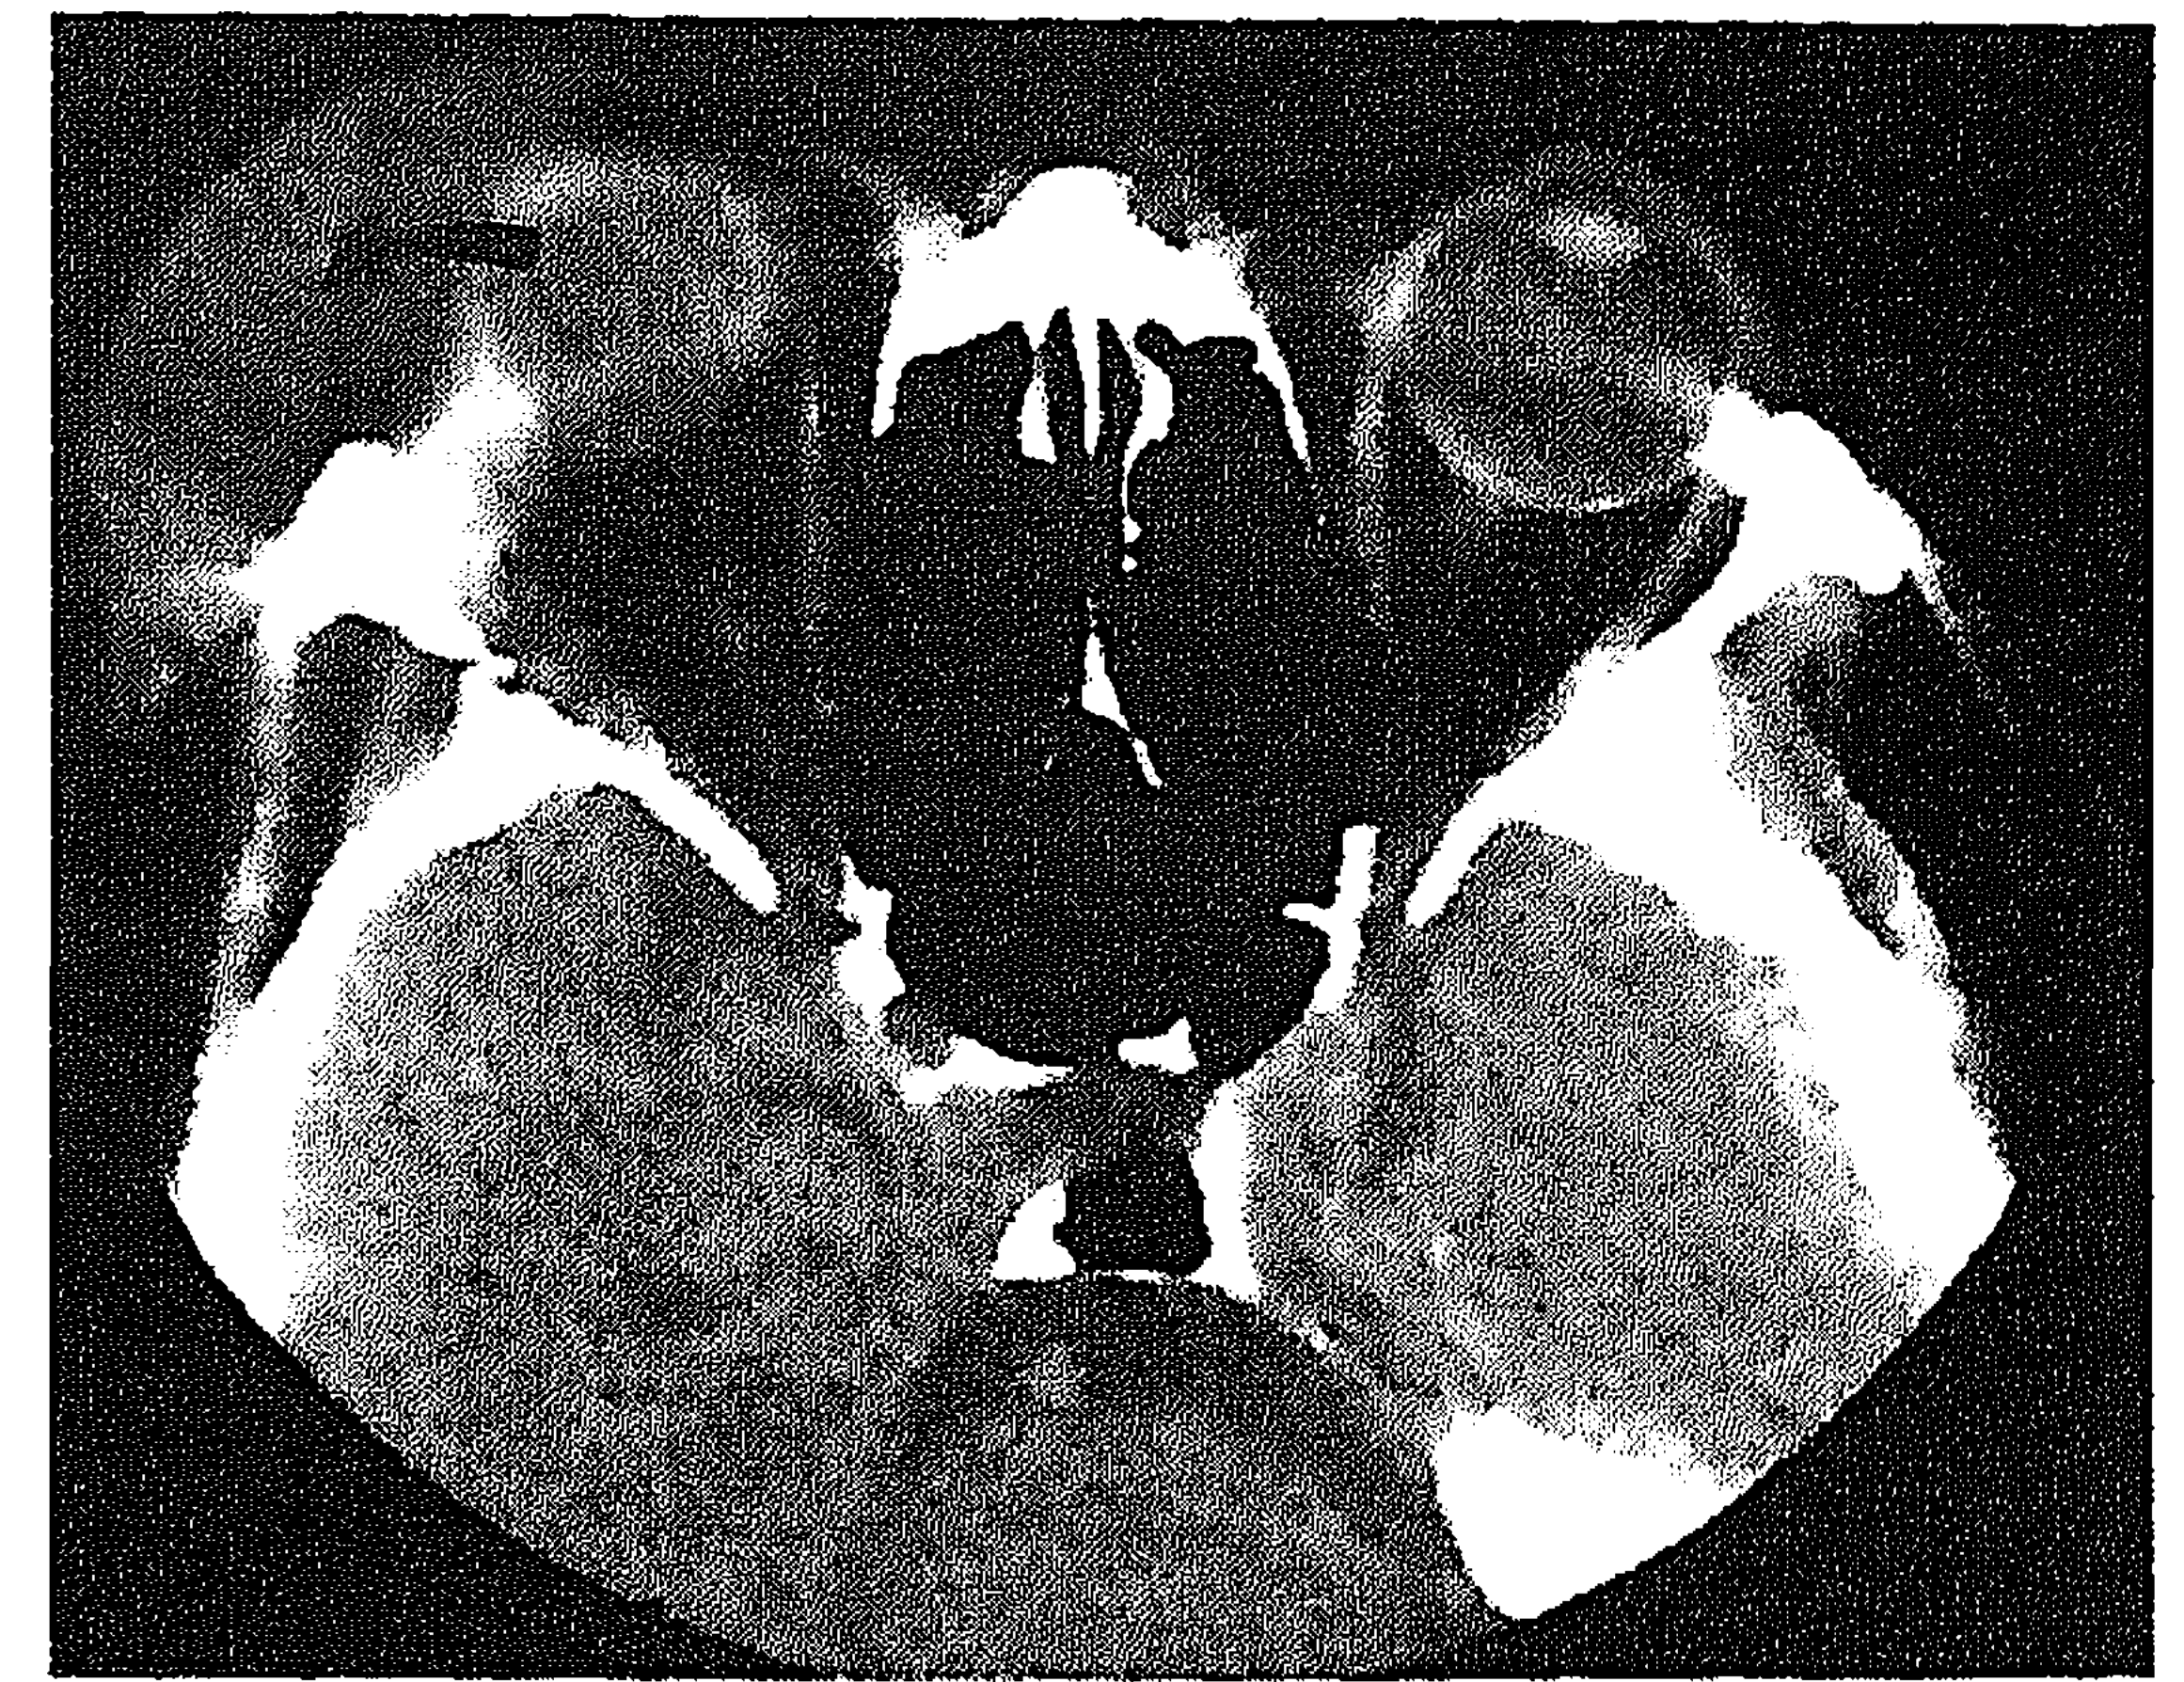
Computed tomography scans of the orbits after corticosteroid treatment but before antimycotics. Axial view, increase in subcutaneous mass (arrow) compared with that shown in Figure 1A.
